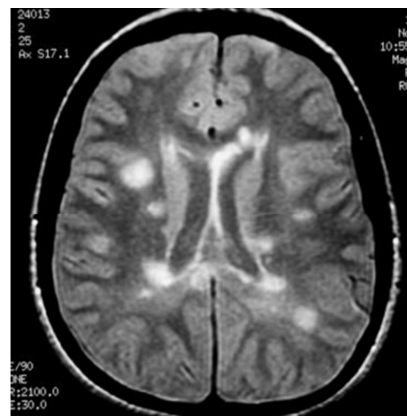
Diffuse white substances in MRI positive for Multiple sclerosis
